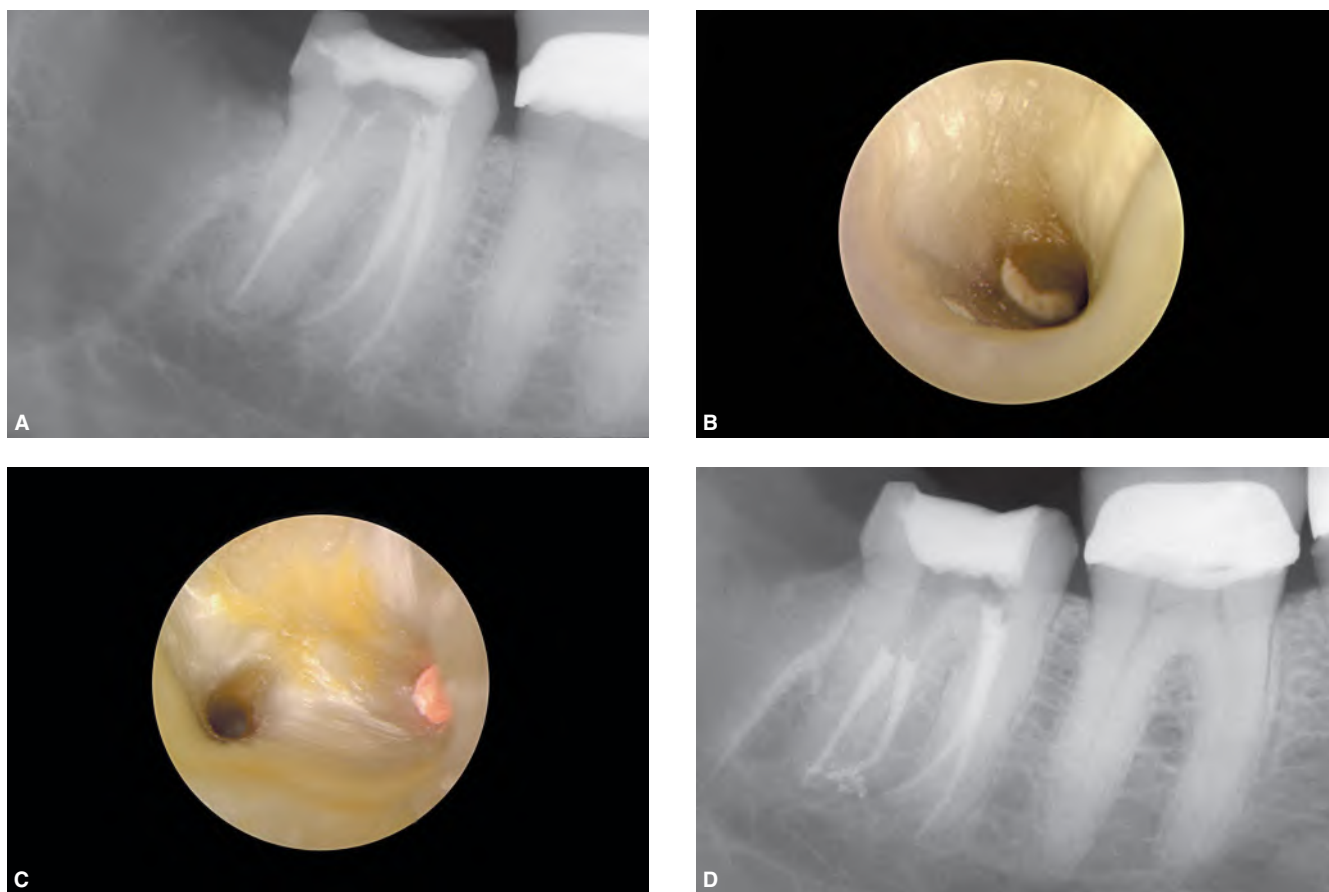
A. Radiograph showing a mandibular right second molar with three canals treated endodontically. The obturation material is not centered within the distal root. B. A view into the centered distal orifice reveals obturation material positioned subcrestally in a fin of this canal. C. Photograph showing improved straightline access to the DL orifice and gutta-percha deep within the previously treated DB system. D. Post-treatment radiograph demonstrates the packed DL root canal system.
